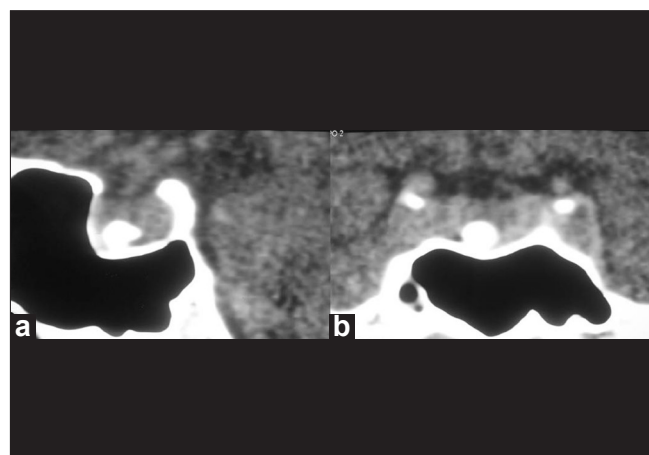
CT sella of the same patient, sagittal reformatted image (a) and coronal reformatted image (b) showing the lesion to be bony and arising from the floor of sella
